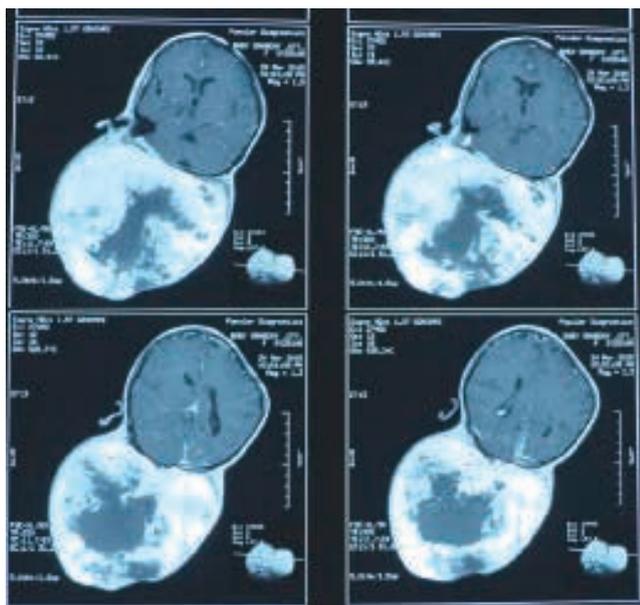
MRI of Brain showed large heterogenous intensity mass lesion in sub-occipital region extending in neck region posteriorly. There is intense heterogenous enhancement in post contrast study
